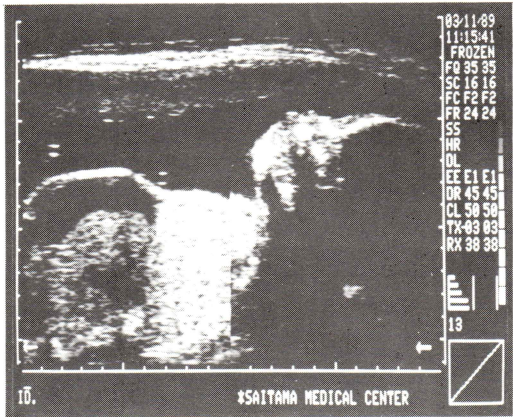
Polyhydramnios and fetal ascites detected by ultrasonography.
